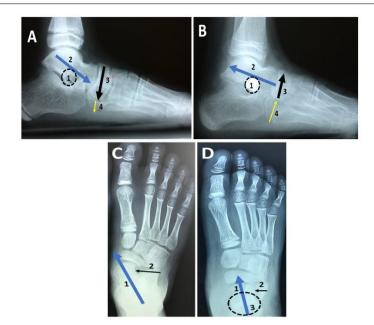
Pre and postoperative weightbearing images. A. Preoperative weightbearing radiograph. A1: Shows the obliteration of the sinus tarsi. A2: Sagittal talar declination and anterior displacement of the talus on the calcaneus. A3: Shows navicular drop. A4: Comparison of the plantar aspect of the navicular compared to the plantar aspect of the cuboid. Postoperative weightbearing radiograph. B1: Is the sinus tarsi implant. B2: Shows realignment of the talus on the calcaneus. B3: Shows elevation of the navicular. B4: Shows an increase elevation of the navicular compared to the cuboid. Preoperative weightbearing radiograph. C1: Shows the bisection of the talus is medial to the navicular. C2: Shows the divergence between the talus and calcaneus. D: Postoperative weightbearing radiograph. D1: Shows reduction of the transverse plane deformity and realignment of the talonavicular joint. D2: Shows reduction of the talocalcaneal divergence. D3: Shows the position of the sinus tarsi implant.
